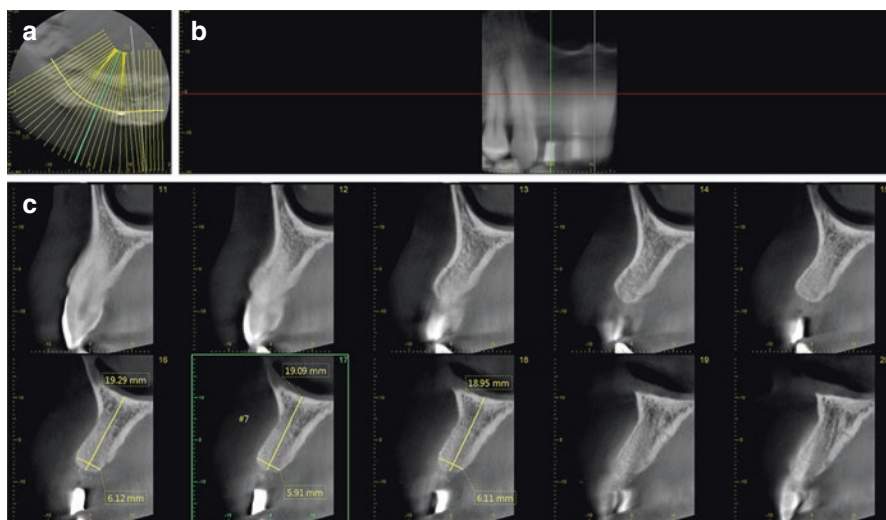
Reformatted CBCT images for implant planning. (a) Axial view depicting the focal trough through the maxillary ridge and locations of the orthogonal alveolar cross sections. (b) Panoramic reconstruction of the anterior maxilla. (c) Alveolar cross sections through the area of teeth #6–8, displaying measurement at the sites of missing tooth #7
